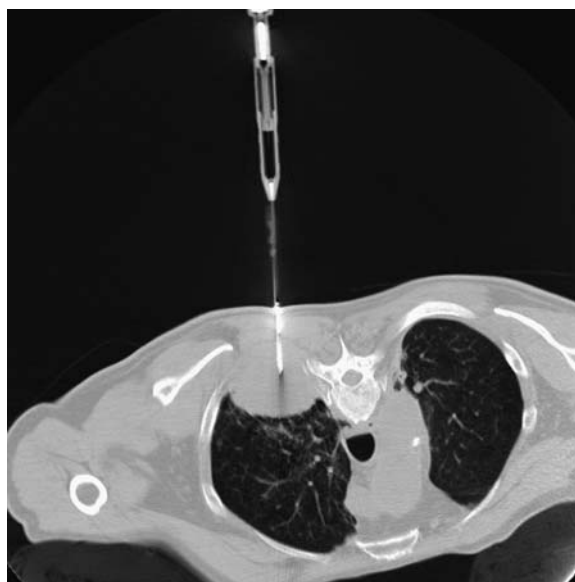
CT-guided RF ablation to right upper lobe lung carcinoma eroding an underlying rib
